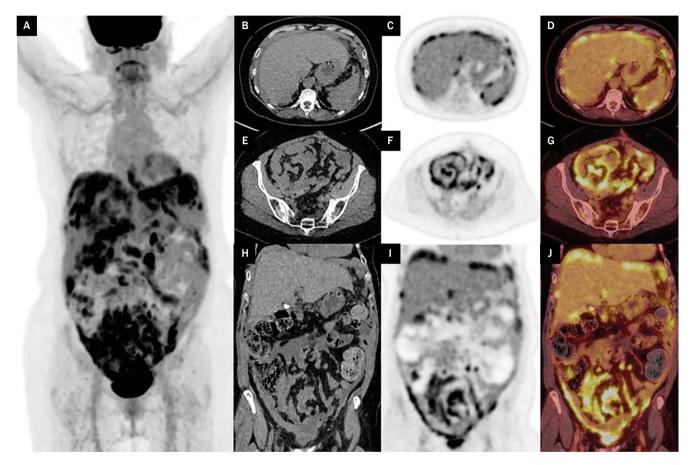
Maximal intensity projection [18F]FDG PET (A), axial CT (B), [18F]FDG PET (C) and fused [18F]FDG PET/CT (D) of the upper abdomen demonstrate intensely avid peritoneal deposits along the peritoneal surfaces with a heavier burden of deposits in the right of the abdomen. Axial CT (E), [18F]FDG PET (F) and fused [18F]FDG PET/CT (G) of the lower abdomen/ pelvis show avid disease coating the small bowel mesentery
